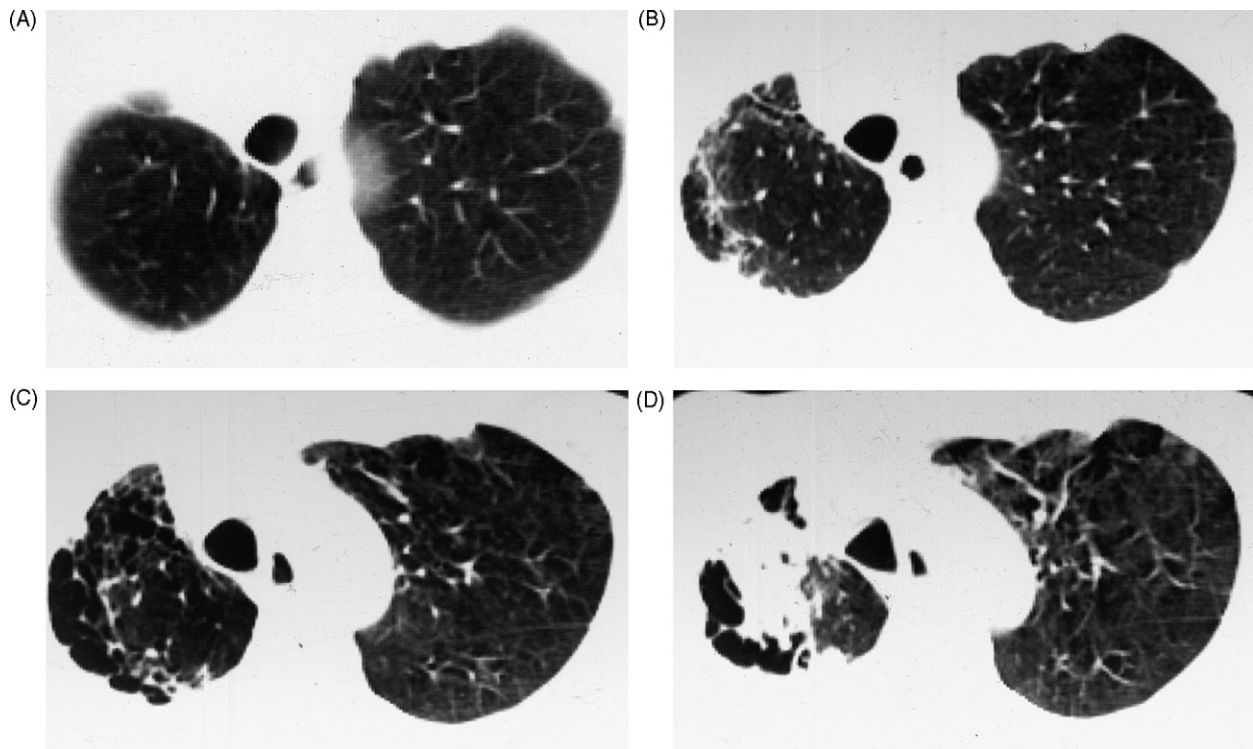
The computed tomographic scan showed a smooth and clear lung margin 2 years after right upper lobectomy (A). Small bullous and fibrous changes occurred at the apex of the re-expanded residual lobe 4 years after the lobectomy (B) and progressed throughout the ipsilateral lung with scarification, lung retraction, and excavated alterations (C; 6 years and D; 7 years after the lobectomy).
